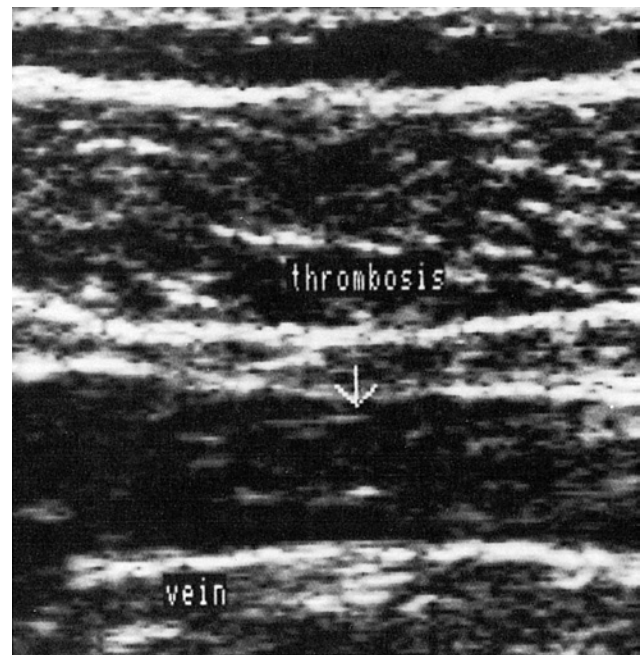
Ultrasound provides clear images of deep venous thrombosis (arrow). A thrombus may appear as an echogenic mass or simply result in the vein being noncompressible.
